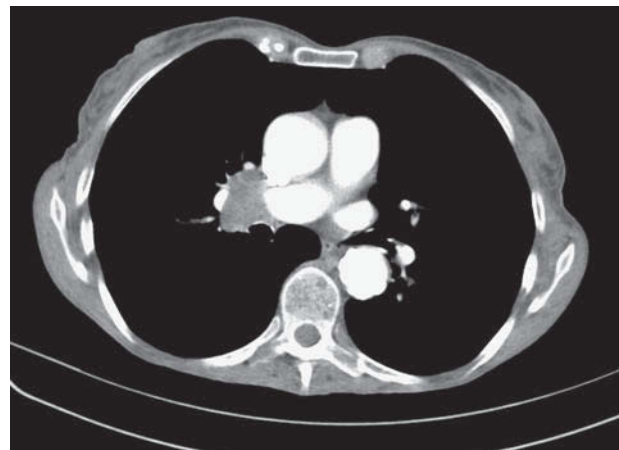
Thoracic CT scan showing a pulmonary mass in the right parahilar region.
